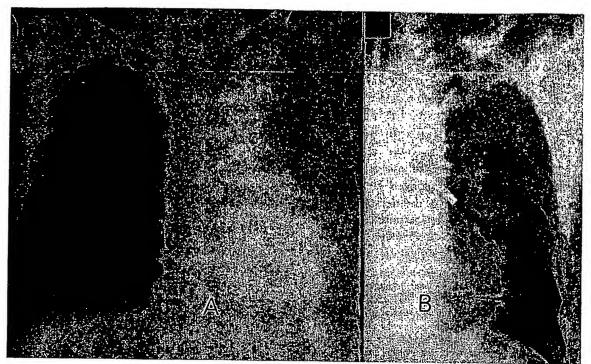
Chest roentgenogram of case 7. A (left): Recurrent atelectasis in left lung re-expanded insufficiently with suction of sputum using bronchofiberscope. B (right): Selective intrabronchial positive pressure ventilation was applied using the bronchofiberscope with cuff, resulting in complete expansion of the atelectatic lung.
